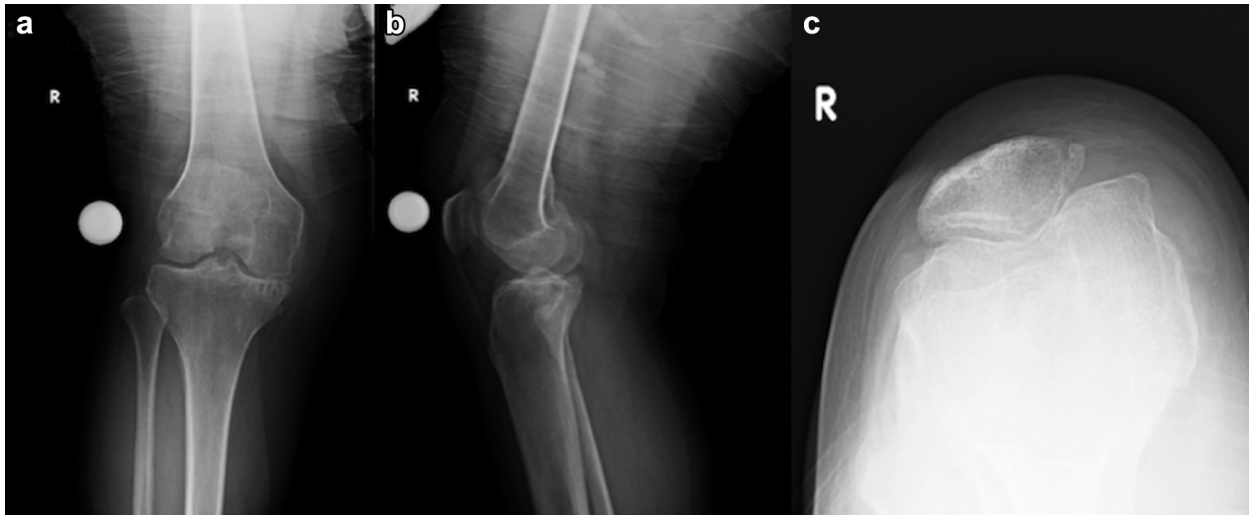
Preoperative (a) anteroposterior; (b) lateral; (c) axial radiographs. There is tricompartmental osteoarthritis manifested by medial tibiofemoral joint space narrowing, subchondral sclerosis, subchondral cysts, and osteophyte formation.
